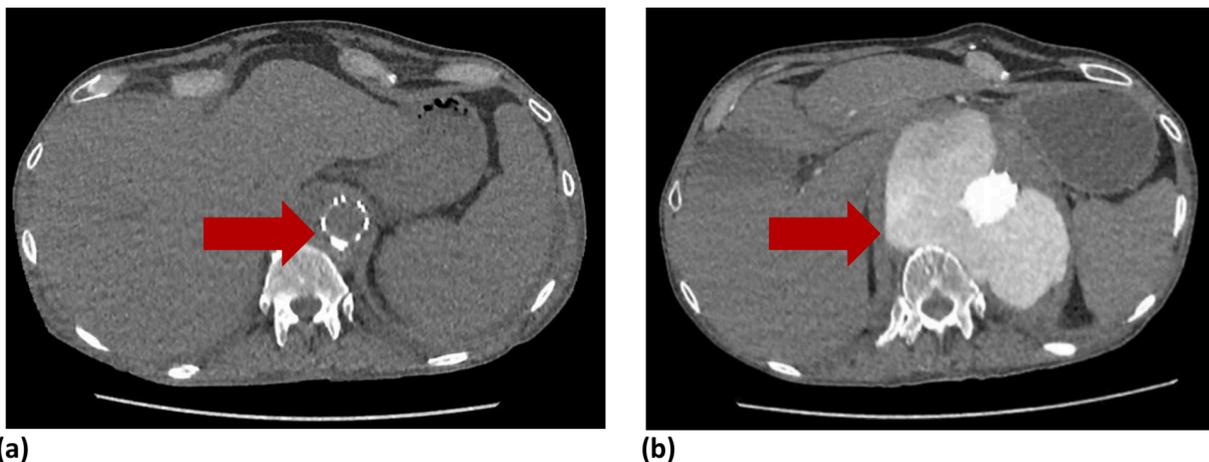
a) Axial section of CT Abdomen showing aortic stent in situ following initial stent insertion. 1. b) Axial section of CT Angiogram prior to death demonstrating enlarged aneurysmal dilatation around aortic stent with loss of fat plane between aorta and posterior structures, findings suggestive of aortic aneurysm rupture.
